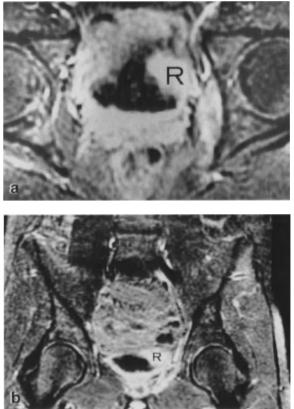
a Axial and b coronal MRI demonstrating bladder wall involvement by soft tissue rhabdomyosarcoma (R) of the pelvis in a 16-year-old male; T1 weighting with gadolinium enhancement and fat suppression technique
